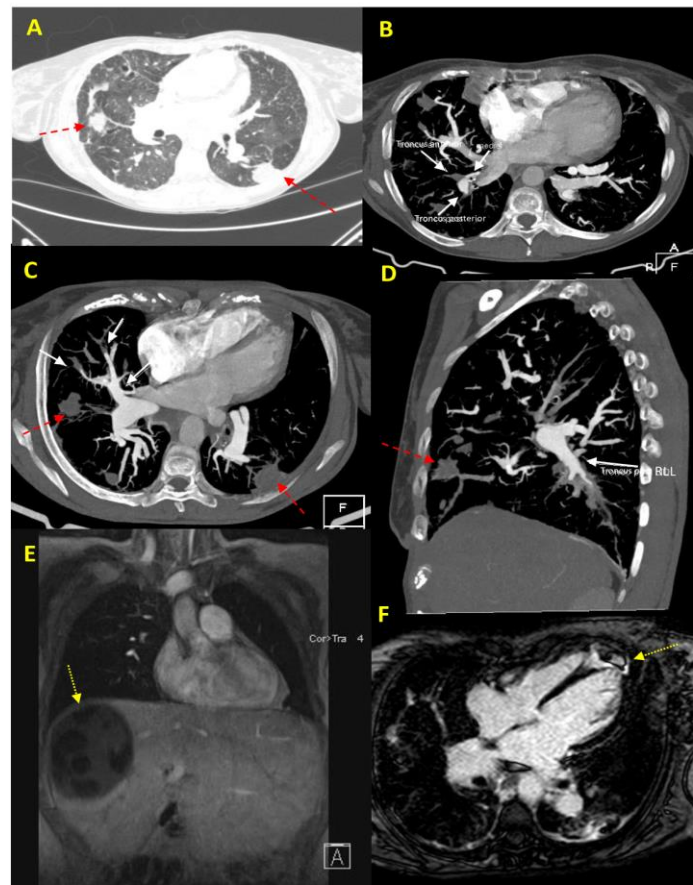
Red arrows show the hydatid cysts in the pulmonary parenchyma (1A, C, D) on computed tomography. White arrows show the filling defects in pulmonary arteries compatible with hydatid embolisms (1B, C, D). Yellow arrows show a big hepatic hydatid cyst (1E) and a hydatid cyst in the apical region of the interventricular septum (1F) on MRI.
